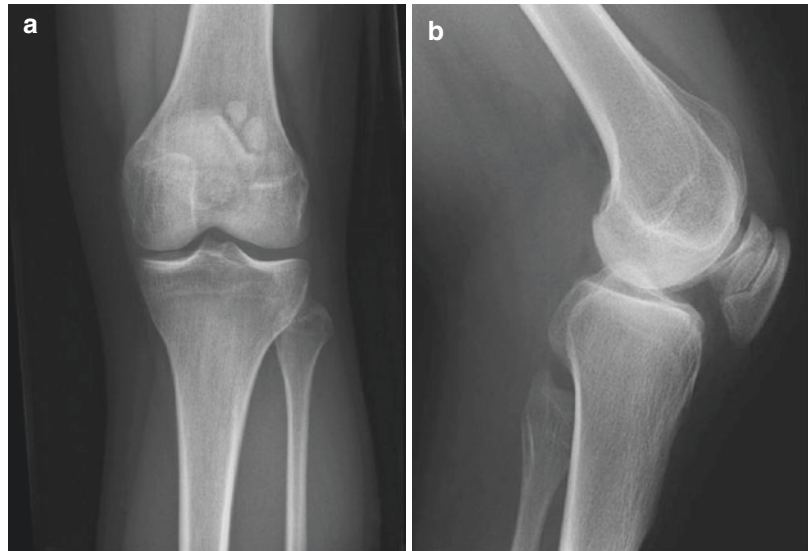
(a) Anteroposterior X-ray of the left knee with a tripartite patella. (b) Lateral X-ray of the knee with the rarest form of bipartite patella, which shows fragmentation in the sagittal plane
